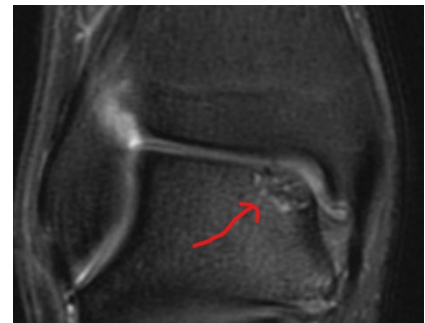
MRI showing medial talar dome OCD
